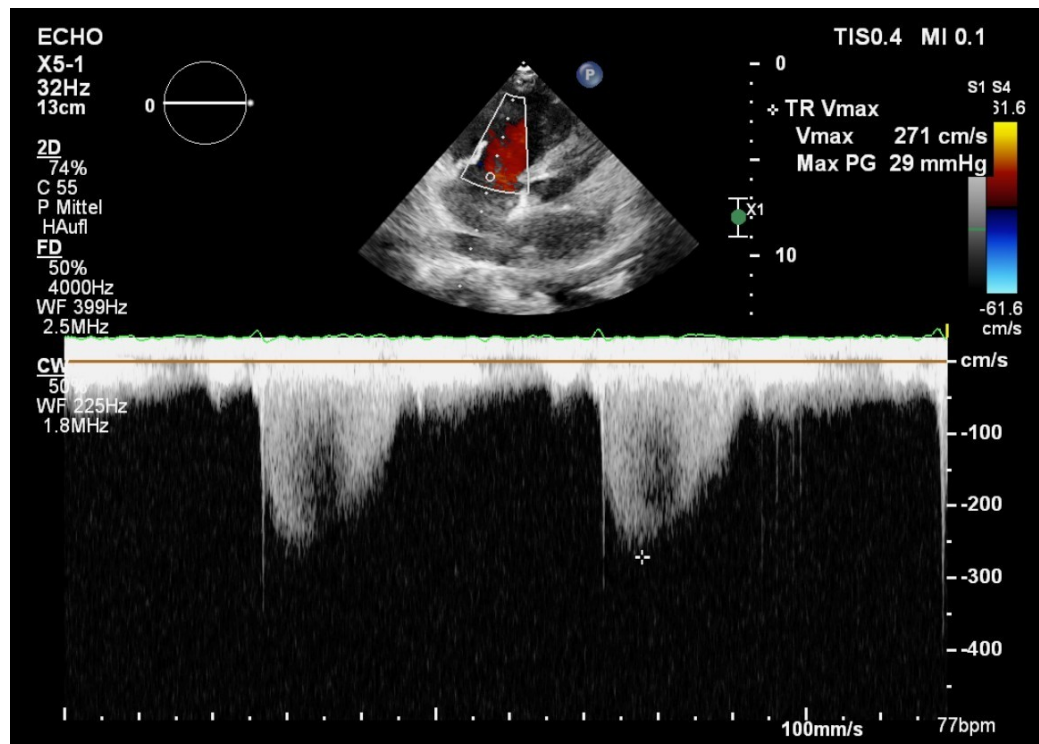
Example of the measurement of TRVmax in the continuous Doppler view; TRVmax is in this case 2,71m/s; TR Vmax, Tricuspid Regurgitant Velocity Maximum; Max PG, maximum pressure gradient
